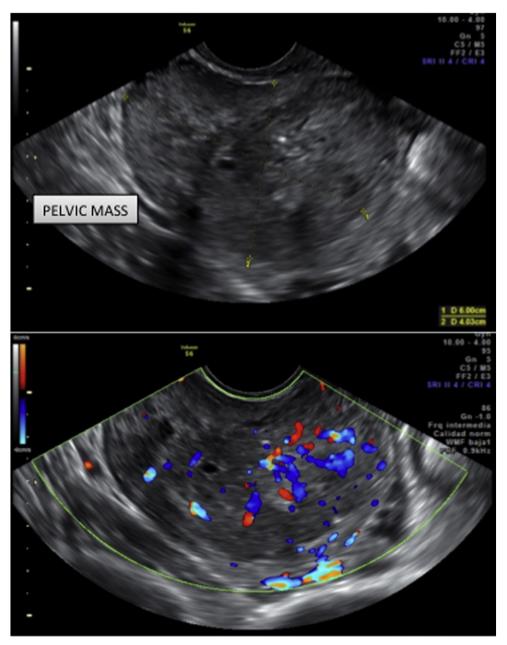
Ultrasound images showing a pelvic mass measuring 60×40 mm.
